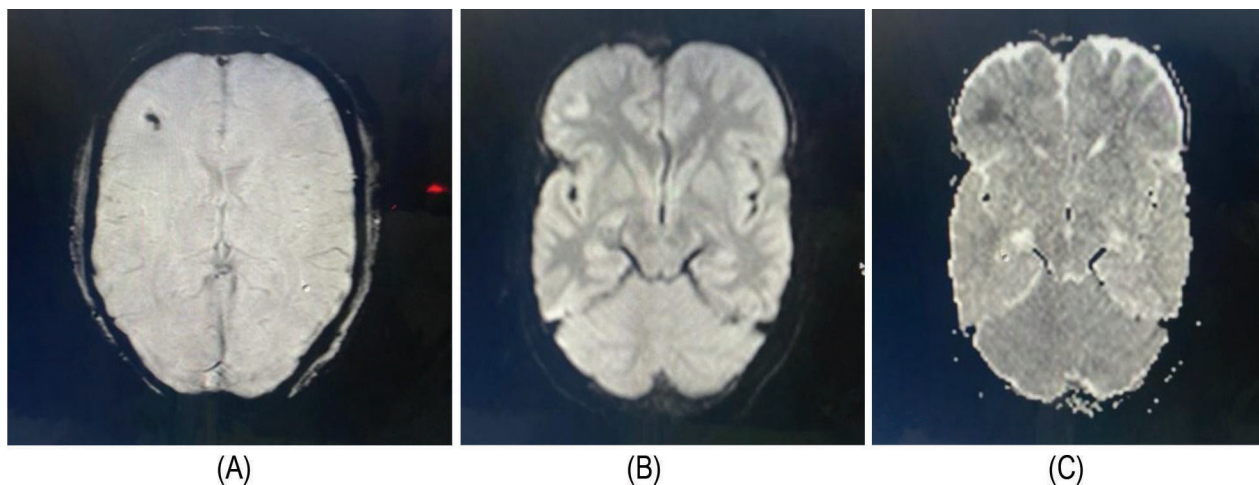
Axial SWI image of haemorrhage in right frontal region showing hypointensity (A), bright on DWI image (B) and dark on ADC image (C).
